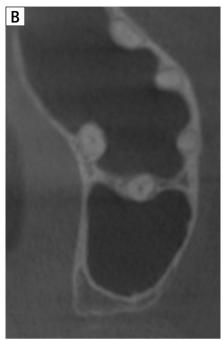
Preoperative assessment of a maxillary molar scheduled for endodontic treatment due to pulpitis. The complex root anatomy and suspected sinus involvement prompted a CBCT evaluation prior to therapy. (A) Periapical radiograph showing a close relationship between root apices and the maxillary sinus floor. (B) CBCT axial slice confirming apical protrusion into the sinus cavity. (C) CBCT coronal view demonstrating the protrusion of all root apices into the sinus.
